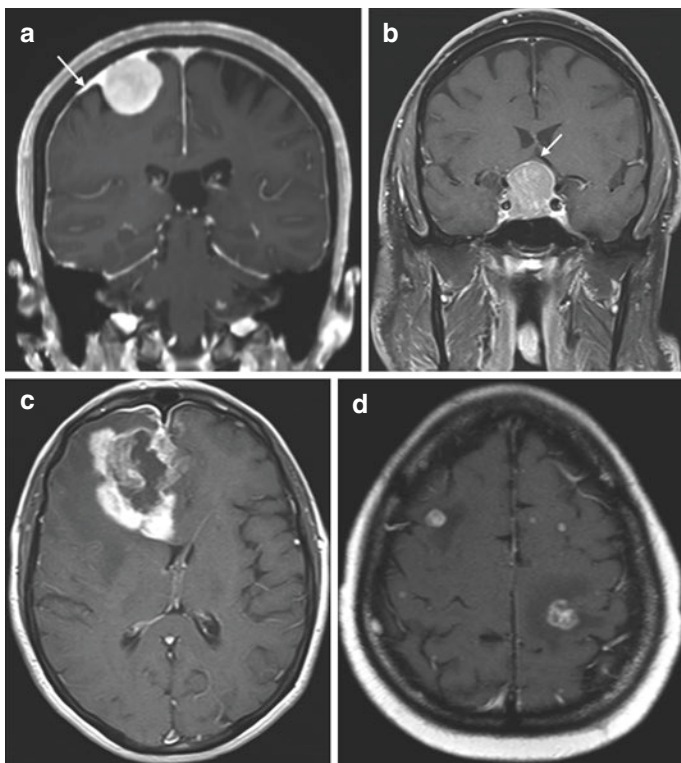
MRI images depicting the most common primary and secondary CNS tumors. (a) Coronal T1 post-contrast MRI demonstrating a convexity meningioma. Note the extra-axial location, homogenous enhancement, and presence of a “dural tail” (*arrow*). (b) Coronal T1 post-contrast MRI demonstrating a pituitary macroadenoma with suprasellar extension and compression of the optic chiasm (*arrow*). (c) Axial T1 post-contrast MRI demonstrating a glioblastoma. Note the intra-axial location, thick peripheral enhancement, and central necrosis. (d) Axial T1 post-contrast MRI demonstrating multiple brain metastases. Note the numerous intra-axial enhancing lesions near the grey-white junction with associated vasogenic edema
